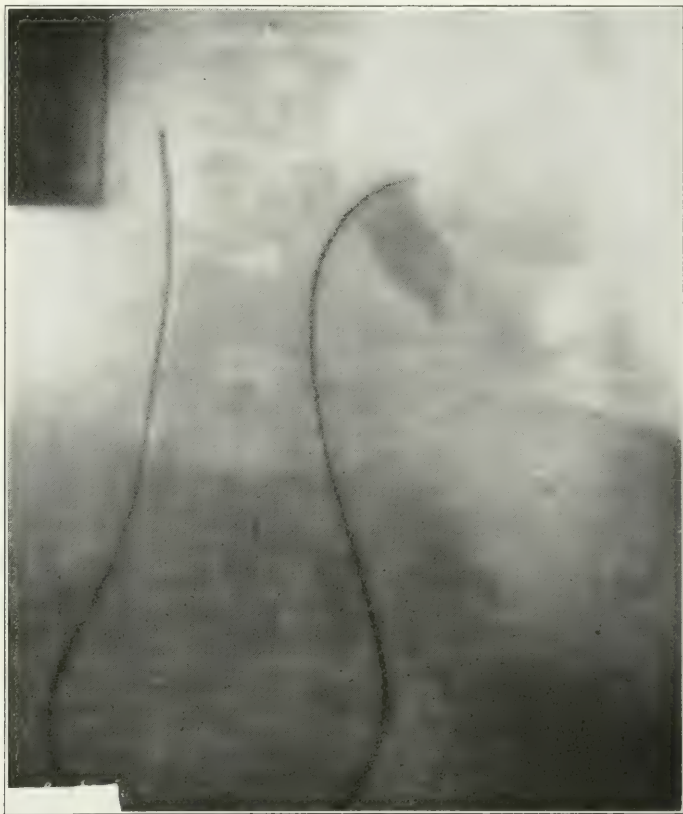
X-ray picture of patient (Case IV) in erect position with 8 c.c. of thorium injected into kidney pelvis. Kidney in a lower position than in Fig. 15. Catheter has passed the constriction.
